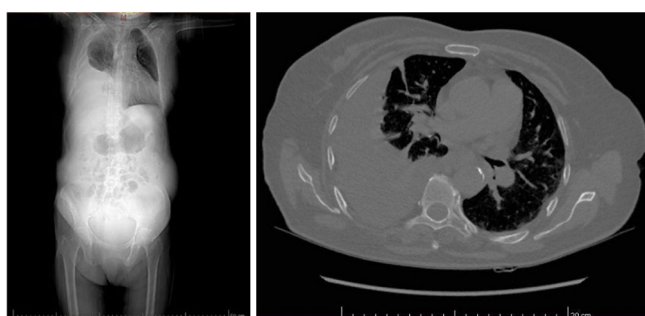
Chest CT: right pleural fluid in large quantities, located apical postero- and latero-basal, with secondary collapse of the adjacent lung parenchyma and mass effect on the mediastinum, shifted to the left.
